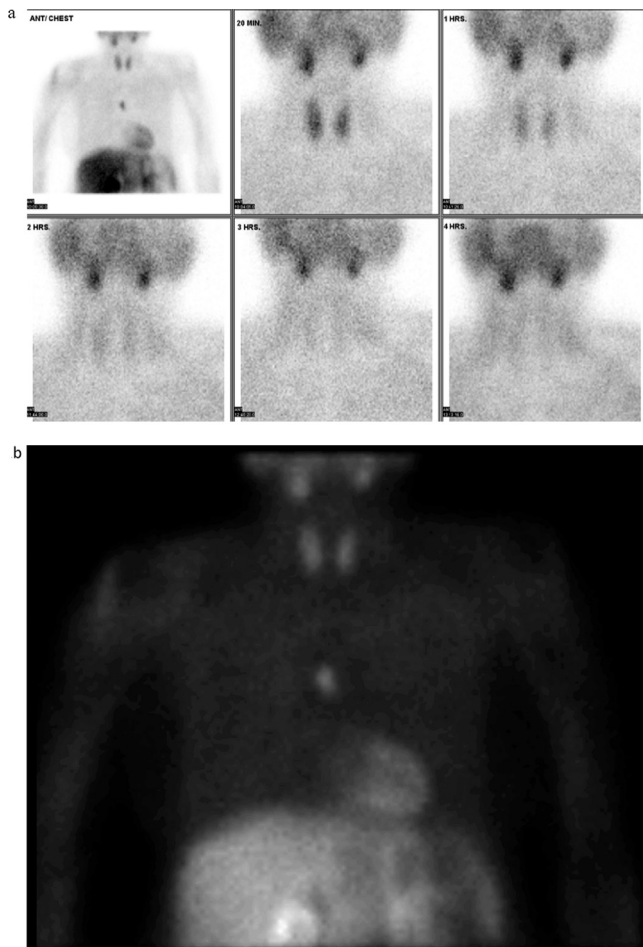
a. 99mTc-MIBI scintigraphy scan demonstrating PTH adenomas. b. 99mTc-MIBI scintigraphy scan demonstrating ectopic PTH adenomas in anterior mediastinum.
